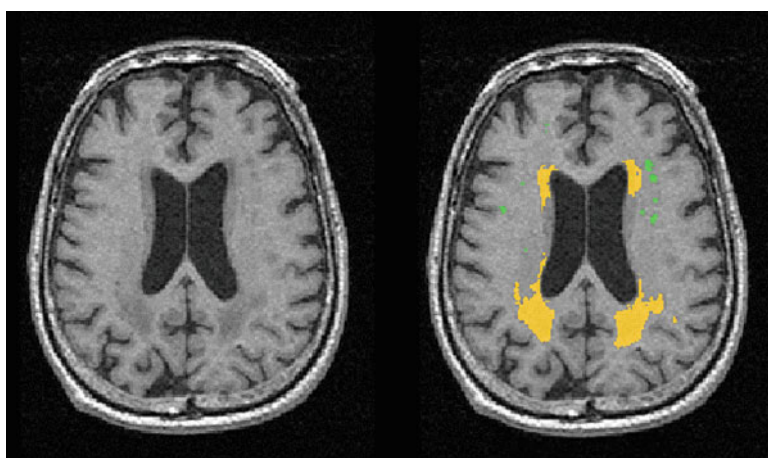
T1-weighted MRI (left) with lesion mask displayed as an overlay (right). White matter hyperintensities appear with a slight hypointensity on T1-weighted MRI (left image) and as bright hyperintense regions on T2- and proton density-weighted images (as they appear in Fig. 4, middle and right images). Lesion mask with orange color represents periventricular white matter hyperintensities, and lesion mask with green color represents deep white matter hyperintensities
